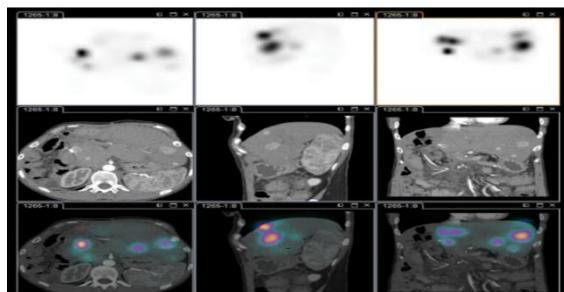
$^{99m}\text{Tc}$ -MAA uptake in liver tumors. The SPECT images (top row), CT images (middle row), and fused SPECT/CT images (bottom row) demonstrate multiple liver tumors with radiotracer accumulation, aiding in pre-TARE mapping and assessment of tumor vascularity.
